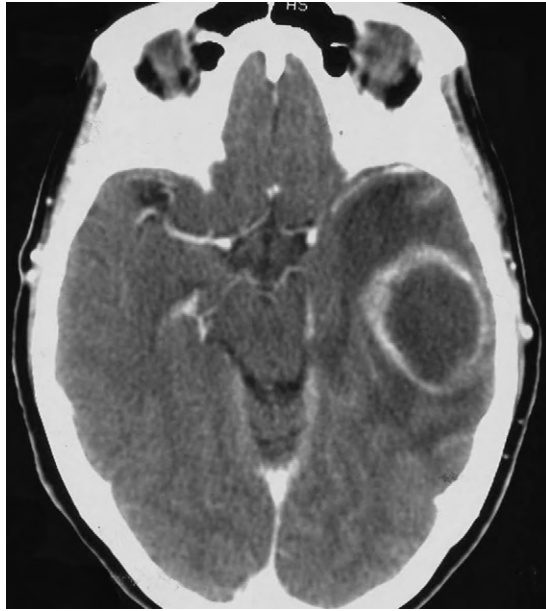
Initial computed tomogram with injection showing a lesion of the left temporal ring that is inducing a midline shift.
